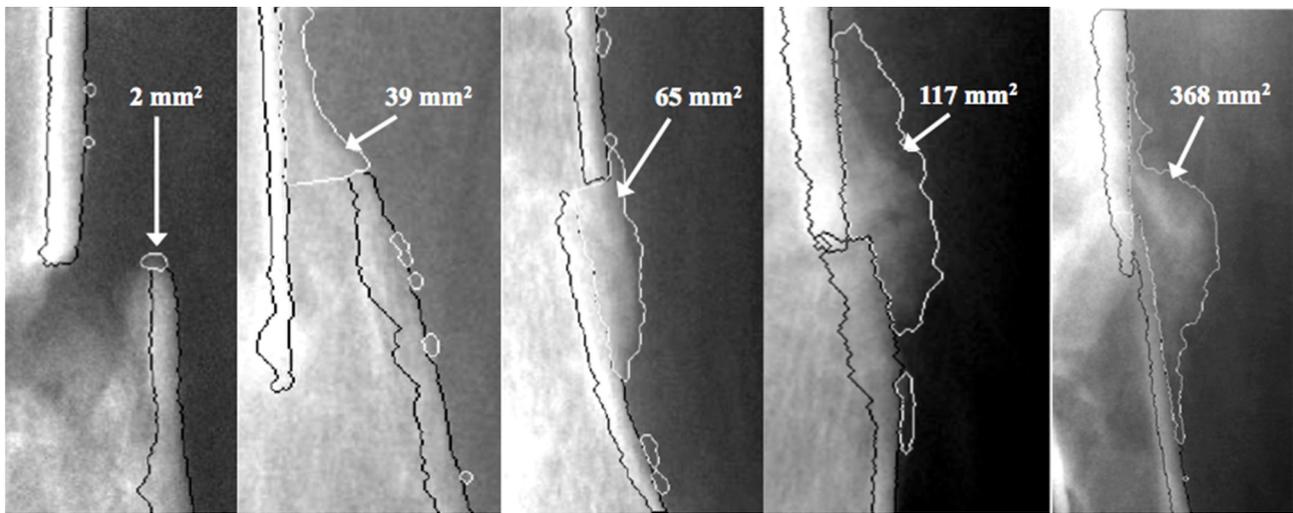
Periosteal callus measured by the computer algorithm. The algorithm outlines the cortex (black line) and callus (white line). These five cases were part of a radiographic series used to validate the algorithm by comparing callus outlined by the computer algorithm vs. callus outlined by clinicians.
